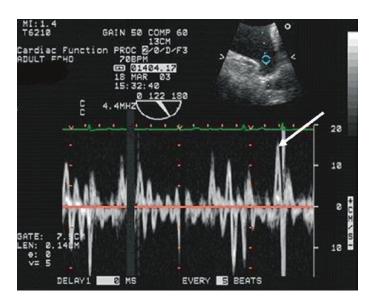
LAA Doppler flow in a patient with atrial fibrillation. Peak emptying velocities (*highlighted*) are markedly reduced (<20 cm/s)
